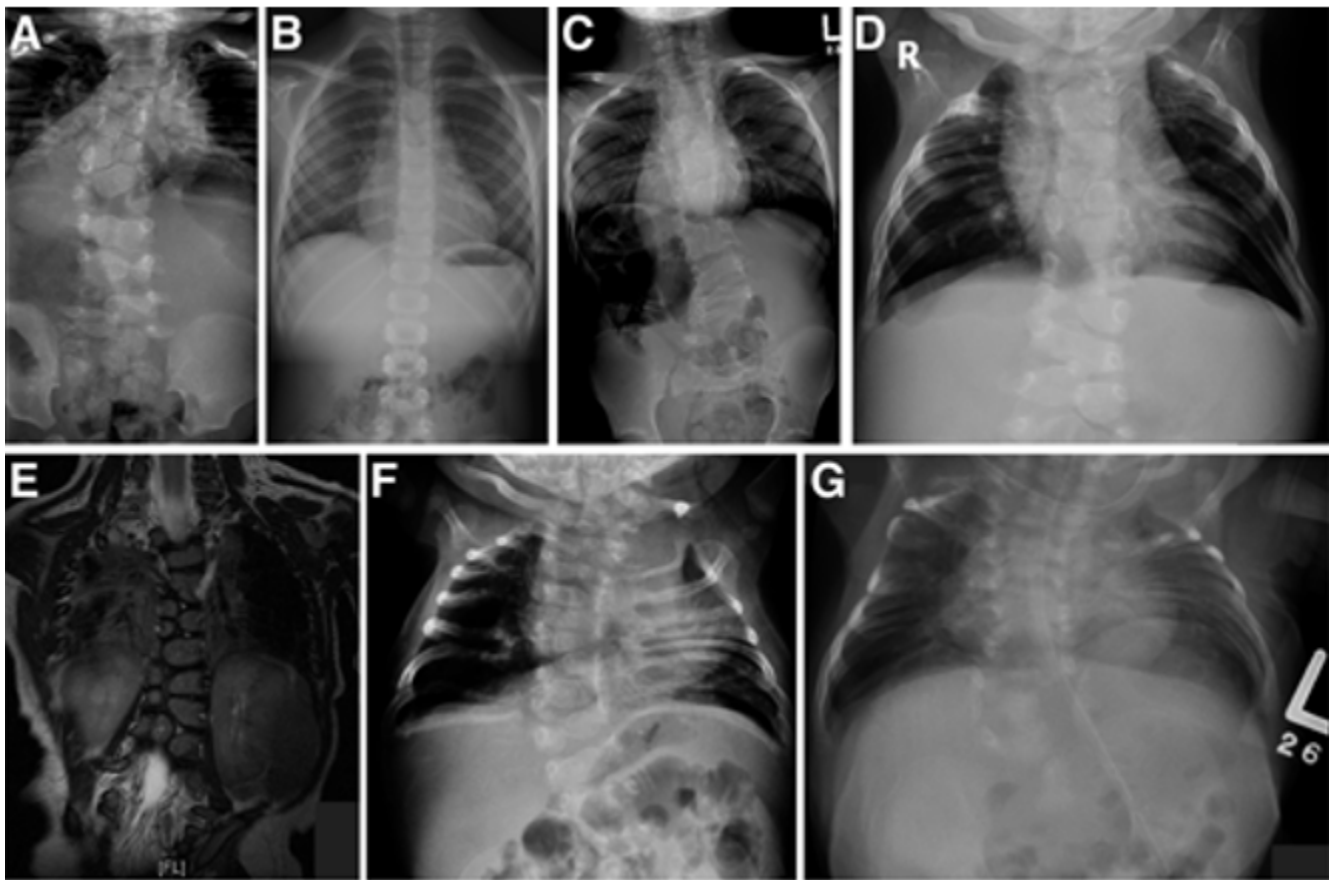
individuals with *HES7*-related SCDO compared to an unaffected individual. X-ray and MRI images showing vertebral and rib malformations and dextrocardia. Seven affected individuals from three families, all with the same homozygous pathogenic *HES7* variant, were reported. Two of the seven individuals had neural tube defects.
